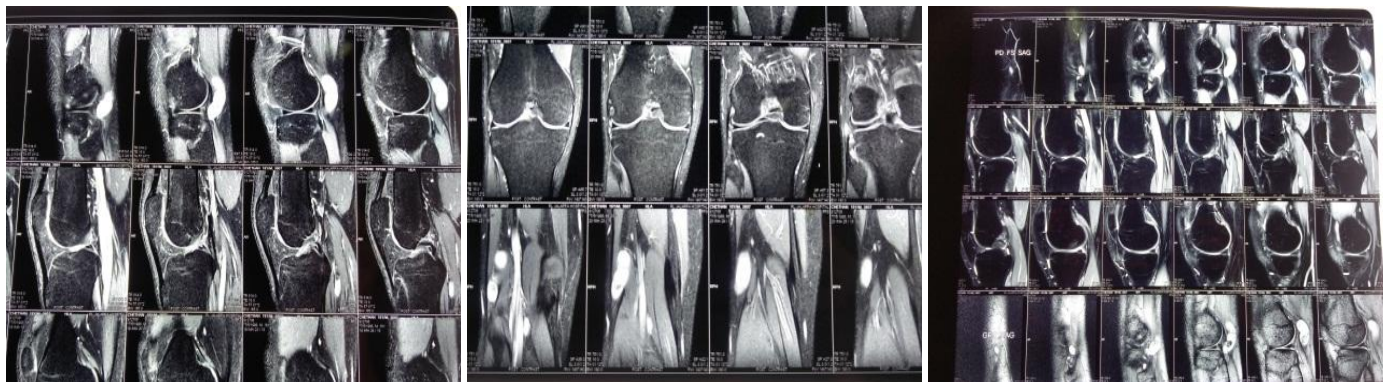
Magnetic resonance images of the knee. (a): axial T1- and T2-weighted images
